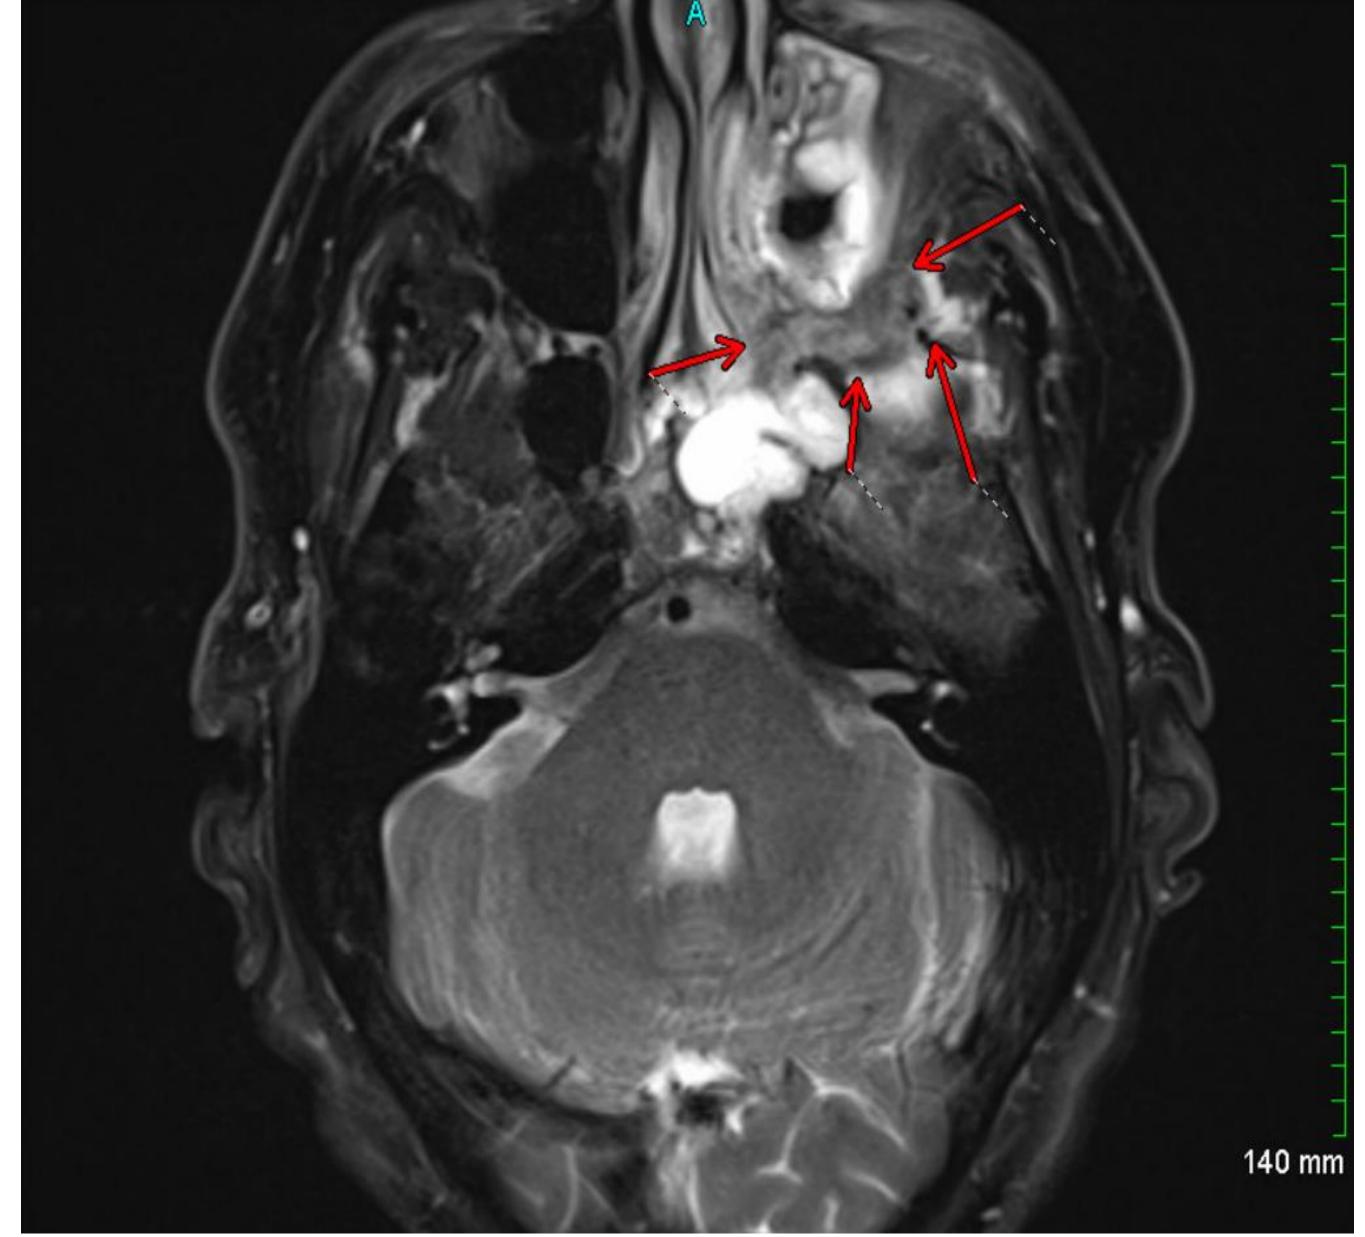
MRI brain and face before treatment
